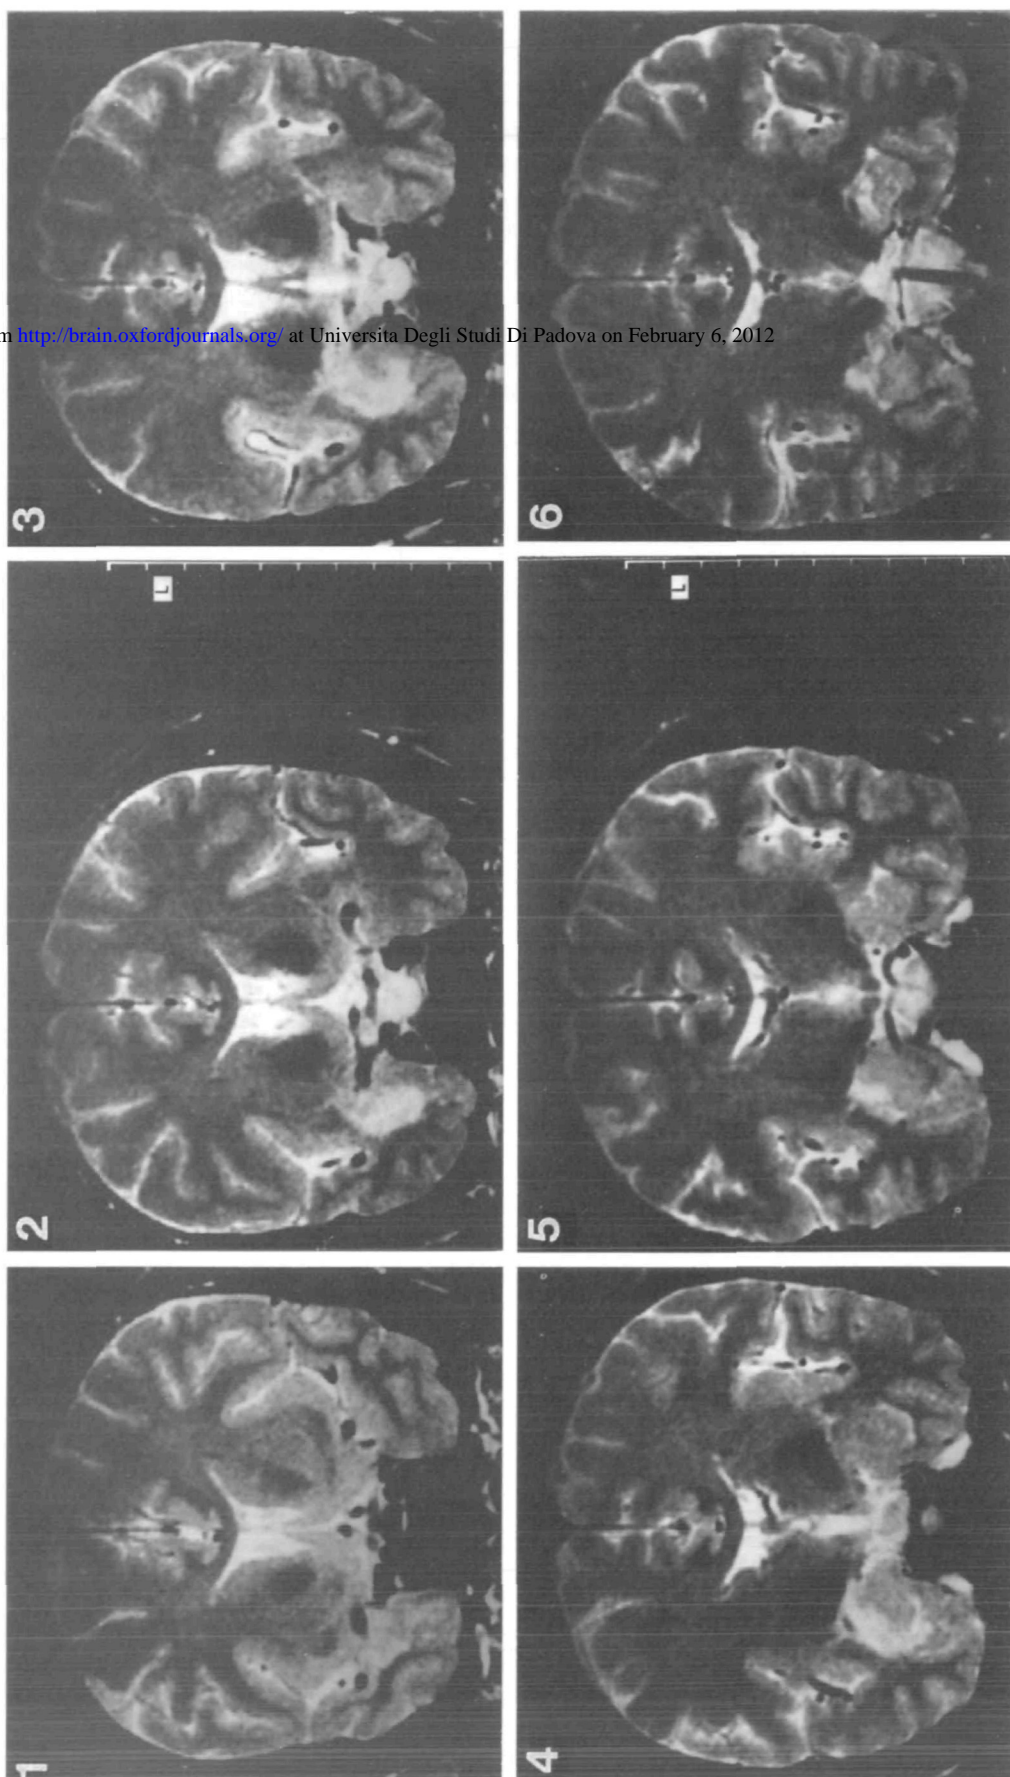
Coronal MRI sections depicting S.G.'s lesion of the right amygdala. The six sections are numbered in a rostral to caudal direction: each section spans 4 mm thickness. On the lower left side (right hemisphere) of sections (2), (3) and (4), the clear hyperintensity area corresponding to the lesioned amygdala is visible. The lesion spans ~14 mm (three or four sections) along the caudal to rostral direction, and spares the hippocampus (section 6).
